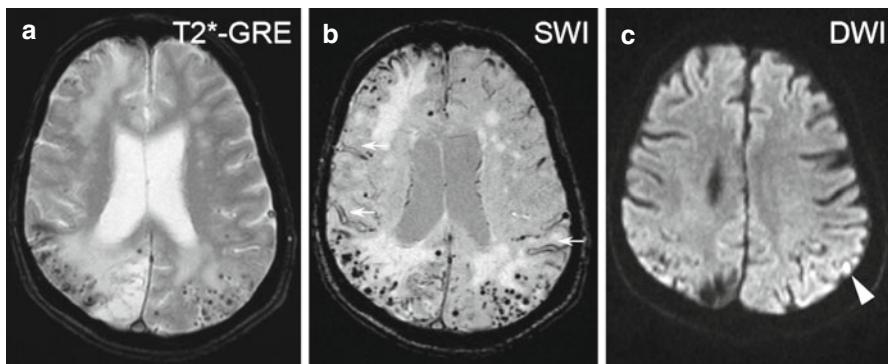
(a) T2*-weighted gradient-recalled echo (T2*-GRE) MRI shows numerous lobar cerebral microbleeds particularly in posterior brain regions characteristic of cerebral amyloid angiopathy. (b) Susceptibility-weighted imaging (SWI) shows even more numerous cerebral microbleeds and extensive cortical superficial siderosis involving multiple cerebral sulci (black serpiginous lines; arrowed). Marked confluent and patchy white matter hyperintensities (leukoaraiosis) are also evident. (c) Diffusion weighted imaging (DWI) shows a small hyperintense lesion (arrowhead) consistent with an acute ischaemic lesion in the left parietal lobe ("microinfarct")
